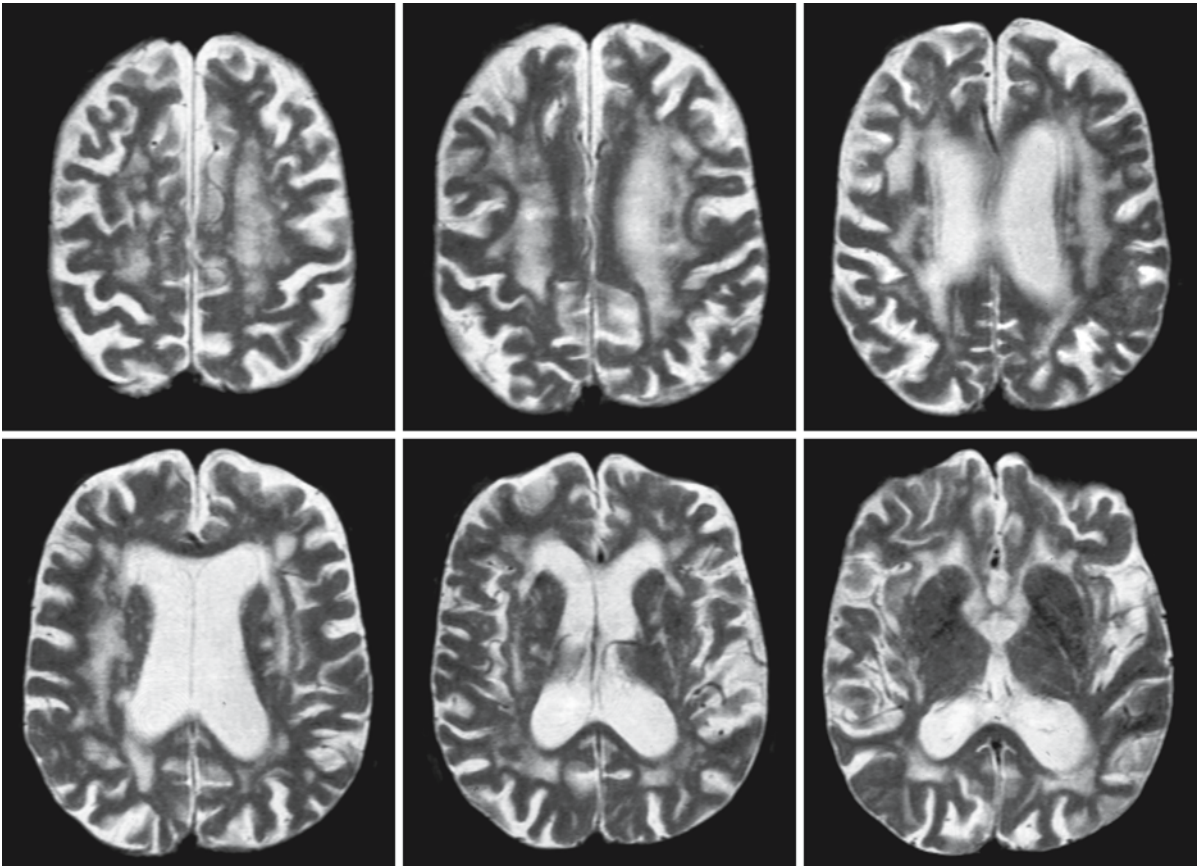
The MRI of this 64-year-old female patient with DM 2 reveals extensive, patchy cerebral white matter abnormalities, sparing the corpus callosum and partially sparing the U fibers. The internal and external capsules are affected. There are spots of abnormal signal in the basal ganglia. The lateral
